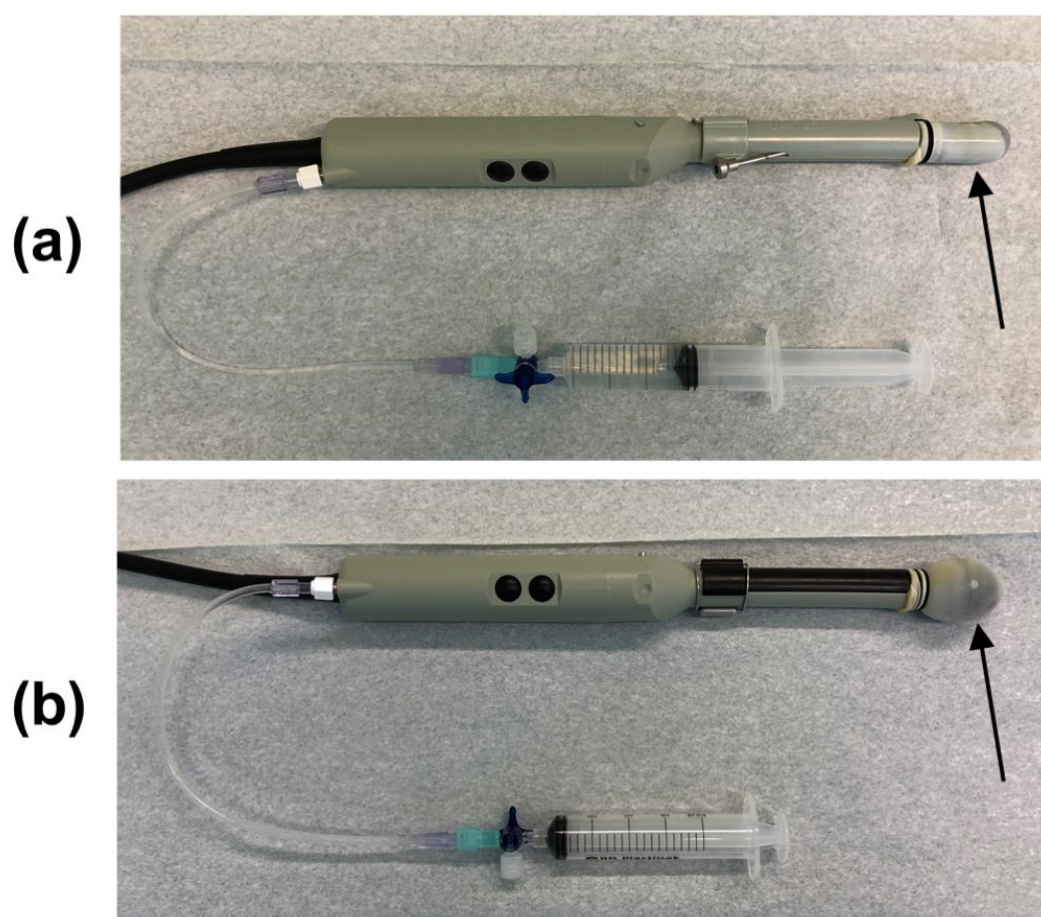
Ultrasound transducer with empty and filled water standoff. (a) Probe mounted with empty water standoff and a biopsy channel bracket (side-fire configuration). (b) Probe mounted with filled water standoff and a dummy channel bracket.
